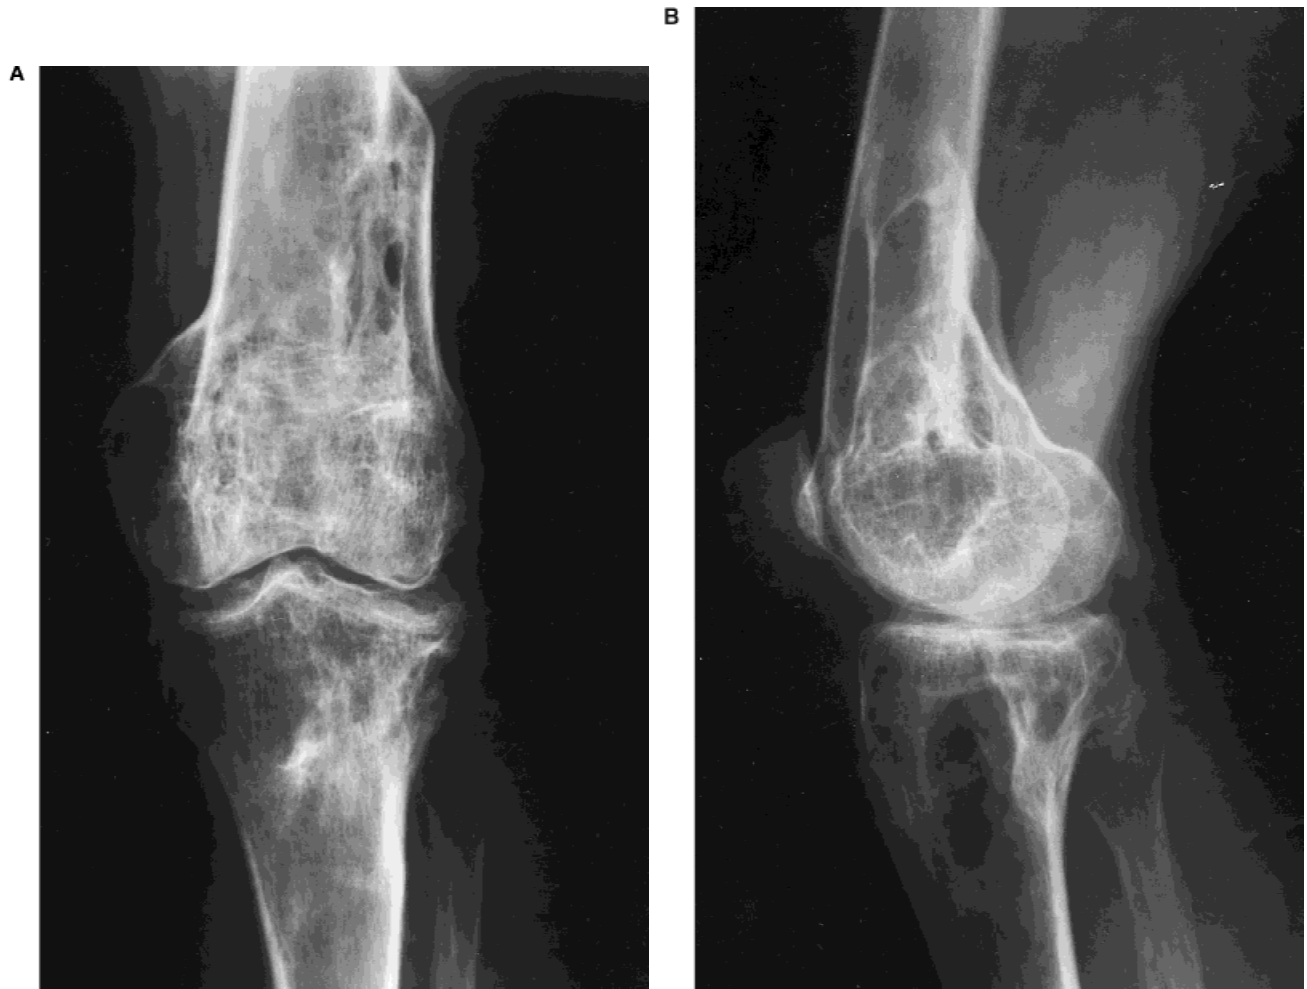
Preoperative radiographs. A: Anteroposterior view shows areas of lucency of medial proximal tibia. B: Lateral view shows well-defined lytic region of osteomyelitis.
